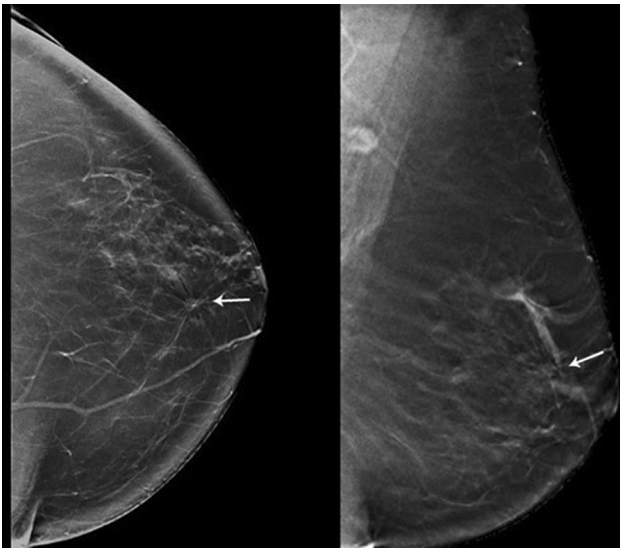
Radial scar. CC and MLO views of the left breast from a diagnostic mammogram in a 62-year-old female demonstrate a 0.8 cm irregular mass in the upper inner quadrant associated with architectural distortion. At 14-gauge core needle biopsy under ultrasound guidance, this was proven to be a sclerosing lesion with ADH
